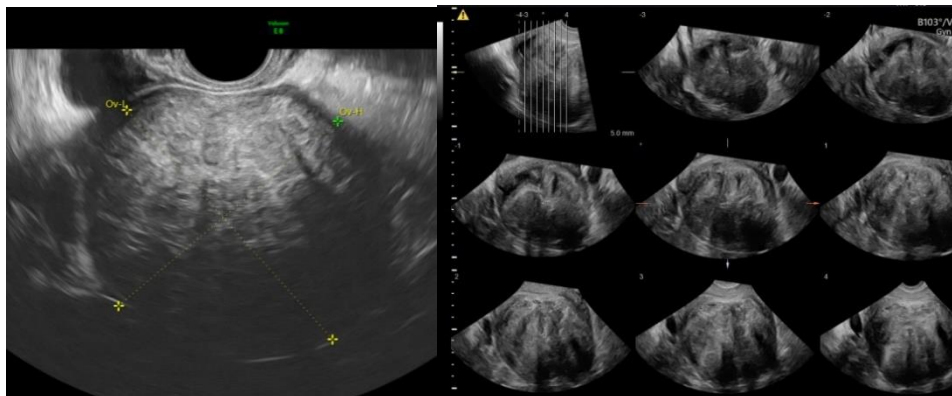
Transvaginal imaging of a typical, oval-shaped uterine leiomyoma with mixed echogenicity and posterior shadowing seen on 2D gray scale (A) and at tomographic three-dimensional ultrasound imaging (TUI)-image (B)
